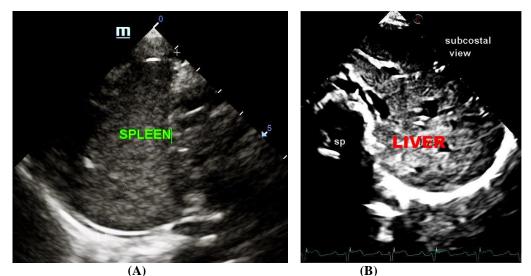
Situs Inversus. Ultrasound of abdomen reveals: (A) Spleen was on the right side; (B) Liver was on the left side; sp, spine.
